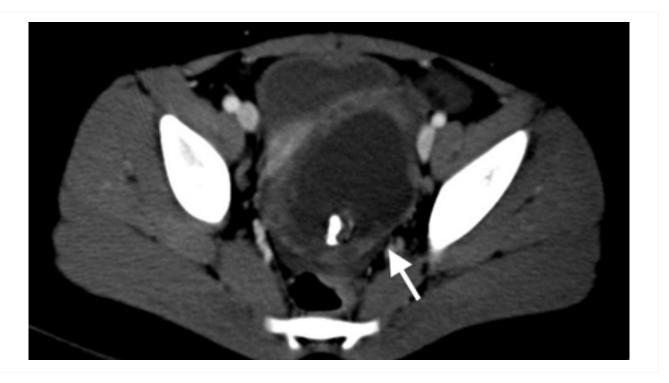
CT scan of a young girl presenting with ovarian torsion. The large pelvic cystic lesion contains calcifications (white arrow) consistent with a teratoma or dermoid cyst
